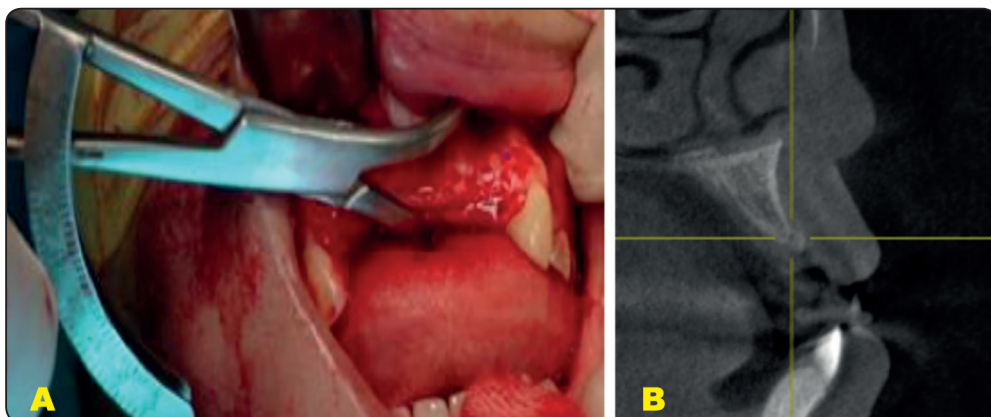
Documenting the ridge width at 3 levels using (A) Caliper; and (B) CBCT cross sectional slices
